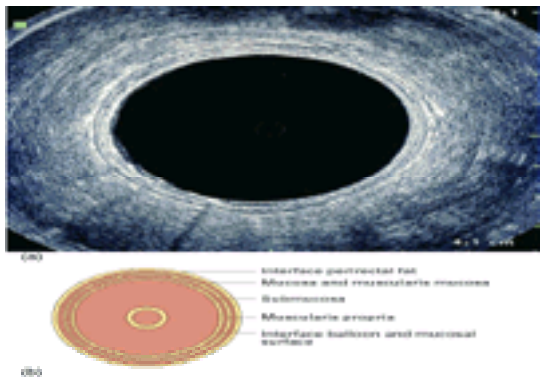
(a) and (b) Normal rectal anatomy on endorectal ultrasound.
